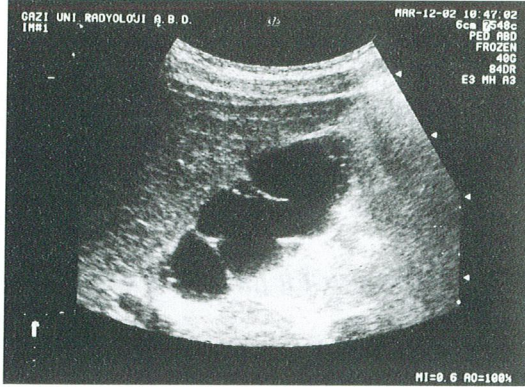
Sagittal ultrasound view of gallbladder demonstrates multiple thin septations.
